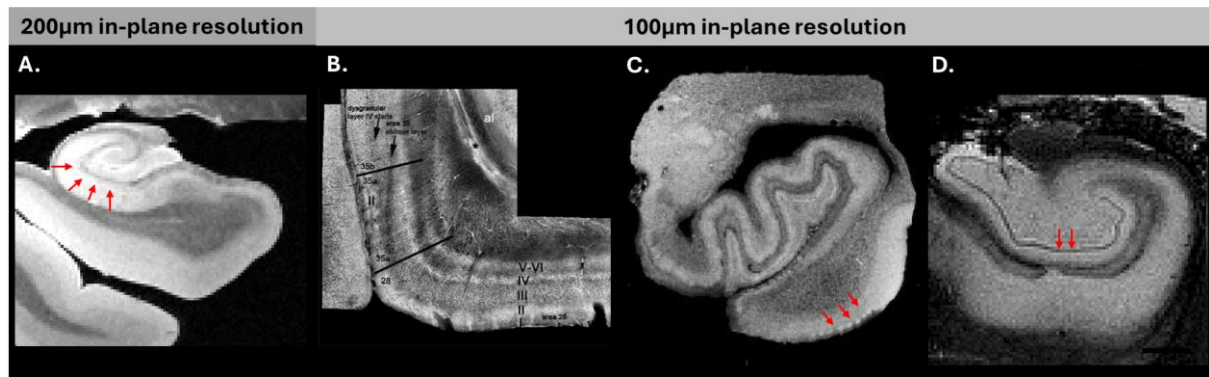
Minimum MRI resolution to visualize key medial temporal lobe (MTL) structures. (A) Dark band corresponding to the stratum radiatum/lacunosum/moleculare (SRLM; red arrows, courtesy of the University of Pennsylvania, Philadelphia, USA). The example shown was acquired at 200 μm isotropic resolution - well above the minimum needed - but prior work indicates that a resolution of at least 0.77 mm in cognitively healthy older adults and 0.52 mm in older adults with Alzheimer's disease is sufficient to reliably identify the full SRLM (Adler et al., 2018). (B) Cortical microstructural layers of the MTL (Roman numerals), reproduced with permission from Augustinack et al. (2014). (C) Layer II "islands" of the entorhinal cortex (red arrows), reproduced with permission from Augustinack et al. (2005). (D) Granule cell layer of the dentate gyrus (red arrows), reproduced with permission from Shih et al. (2023). At least 100 μm resolution is required to distinguish cortical layers, layer II entorhinal "islands", or the granular cells of the dentate gyrus.
